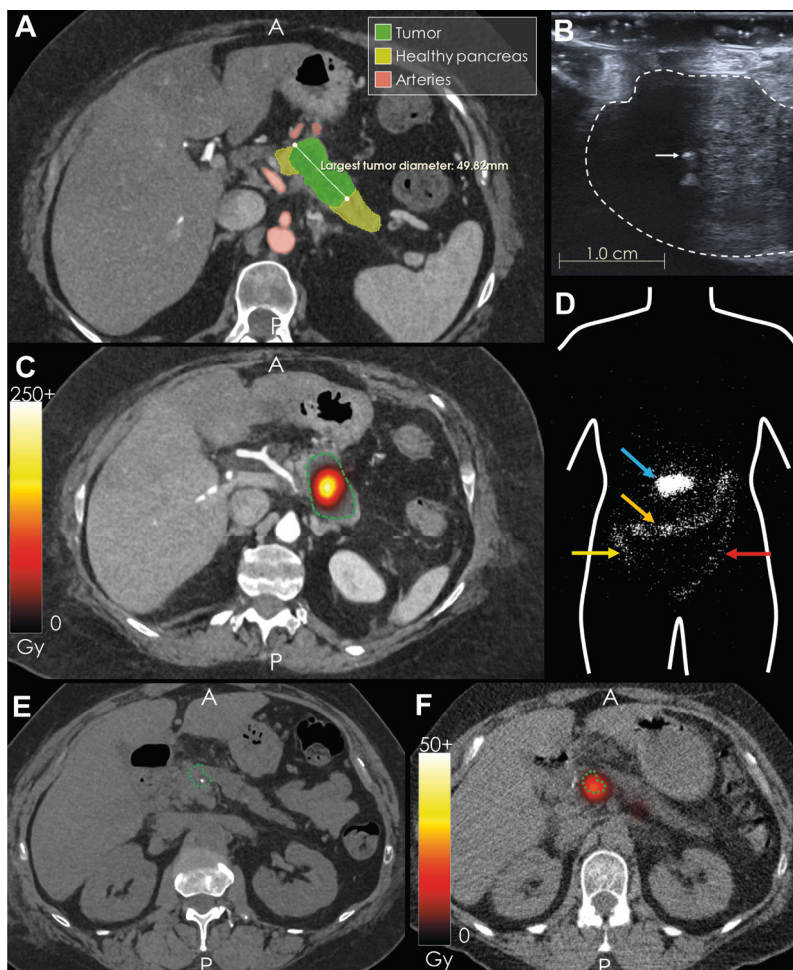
Results from intratumoral injection (ITI) of holmium-166 microspheres ($^{166}\text{HoMS}$). (A) Preoperative ITI planning. Patient 3; (B) Intraoperative ultrasound (US) to assess the tumor size and guide the needle during injection. Tumor: white-dotted line, needle tip: white arrow. Patient 2; (C) SPECT-CT in plane with Figure 1A. Tumor (green dotted line). Patient 3; (D) Planar gamma camera image. Tumor region: blue arrow, ascending, transverse and descending colon: yellow, orange, and red arrows, respectively. Patient 2; (E) Noncontrast CT 24 hours after $^{166}\text{HoMS}$ ITI. $^{166}\text{HoMS}$: white dot, tumor: green dotted line. Patient 2; (F) SPECT-CT in plane with Figure 1E. Tumor: green dotted line. Patient 2.
